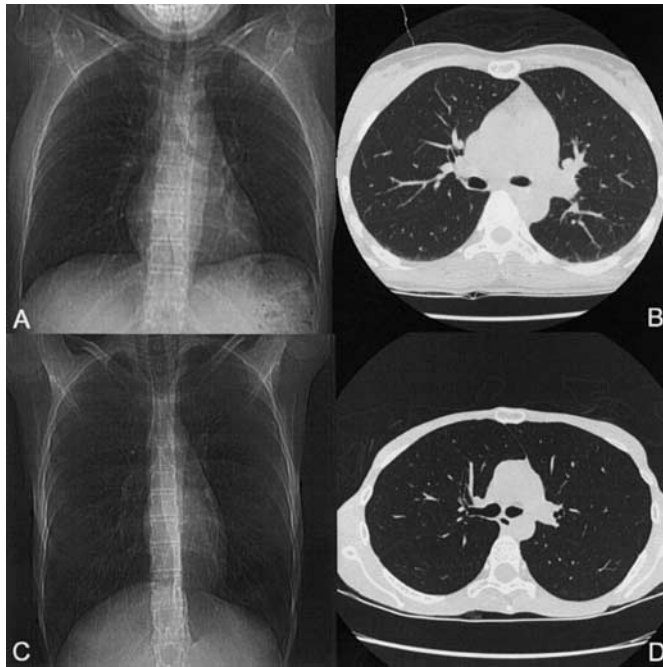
Representative posterior-anterior computed tomography (CT) "locating scout" and thin-slice CT image from a control patient (A and B) with a body mass index (BMI) of 19 kg/m² and the patient who was anorexic (C and D) with a BMI of 12 kg/m². CT images are 1.25-mm thick images reconstructed using an edge-enhancing algorithm (window width = 1,500, window level = -600). The quantitative analysis was performed using thick slice images (5 mm) and an intermediate spatial frequency reconstruction algorithm.
